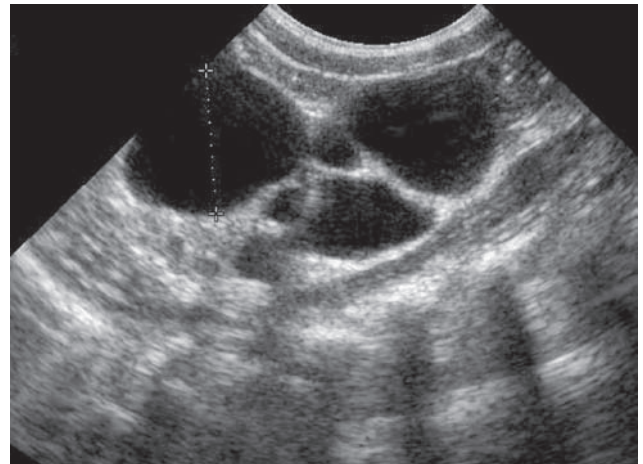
Multicystic dysplastic kidney. Longitudinal ultrasound image of the left kidney reveals several cysts of different size within the kidney. The cysts are non-communicating. No normal renal parenchyma is identified
